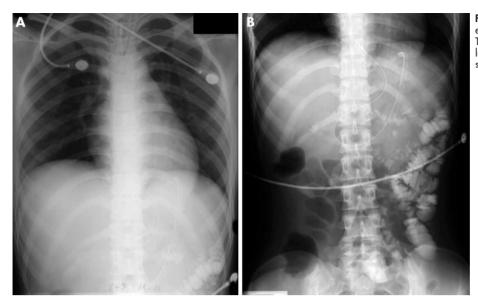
(A) chest radiograph shows endotracheal tube and nasogatric tube. There are no abnormal findings in the lung fields. (B) Abdominal radiograph shows contrast material in the bowel.
